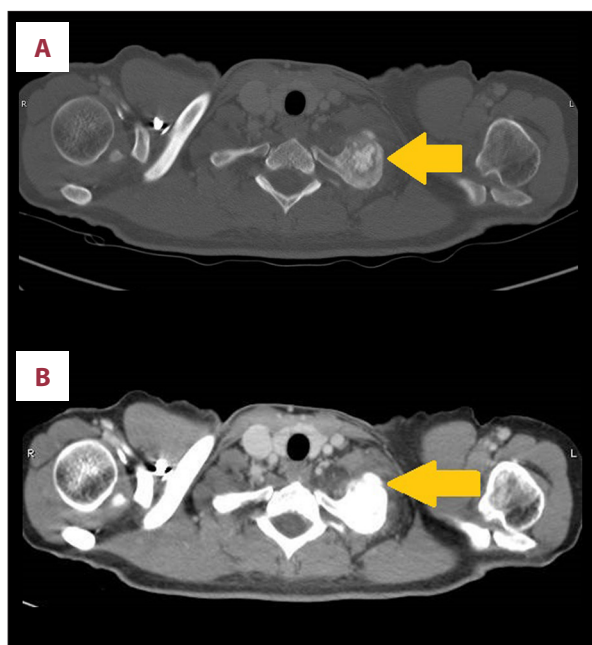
(A, B) CT scan of the chest showing a well-defined exophytic bony lesion with osseous matrix arising from the left first rib (arrows).
